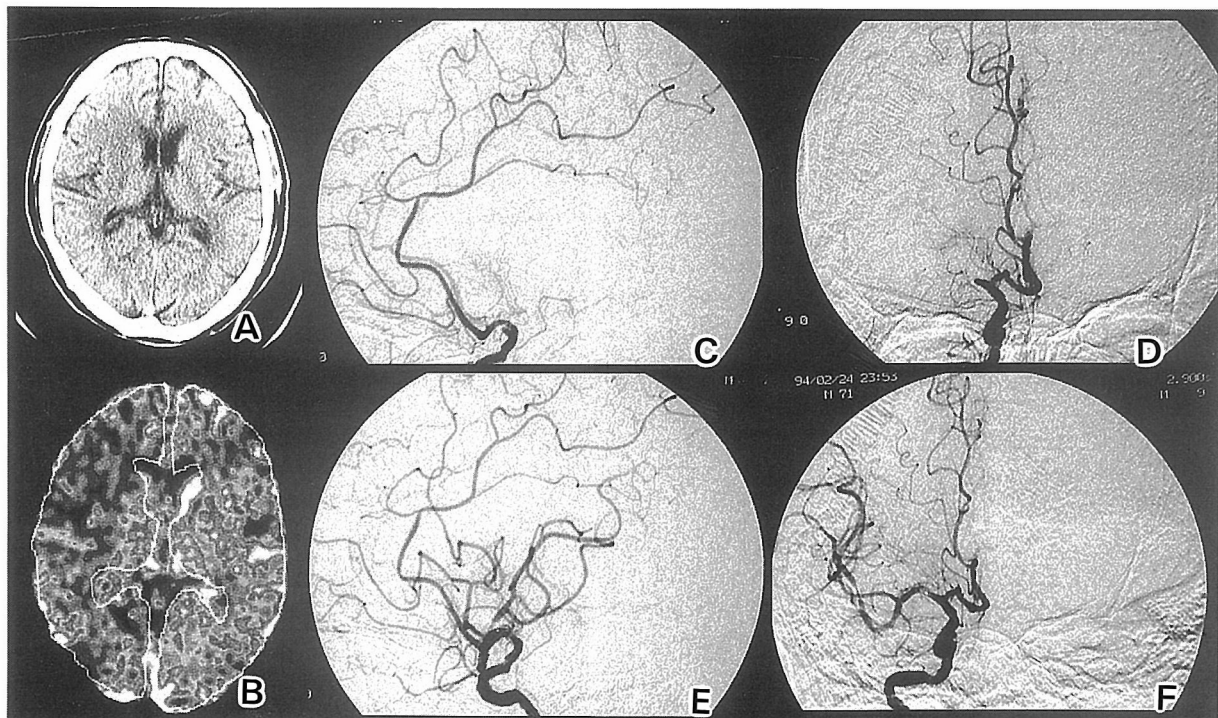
CT image, Xe-CT and angiograms of 71-year-old man with occluded right middle cerebral artery. A: CT image on admission showing no abnormal findings. B: Xe-CT. The CBF is reduced in right MCA territory. C-D: The right carotid angiography on pre-thrombolysis showing right middle cerebral artery occlusion. C: lateral view, D: antero-posterior view. E-F: The right carotid angiography on post-thrombolysis showing recanalization of occluded middle cerebral artery. E: lateral view, F: antero-posterior view.
